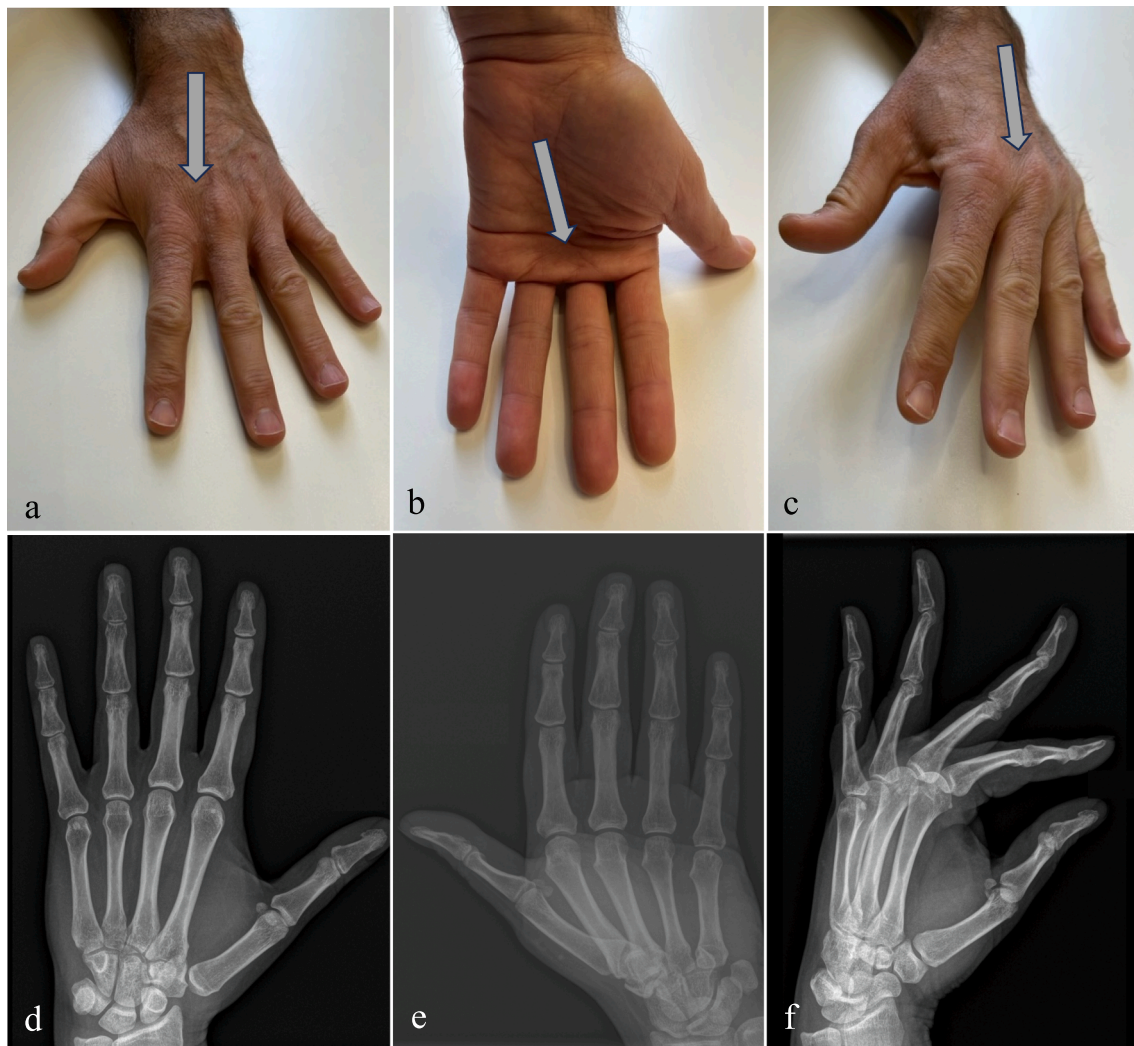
Standard radiographs of the MCP joints of the long fingers. Posteroanterior view (a, d), Brewerton view (b, e), oblique posteroanterior view in semi-pronation (c, f).
